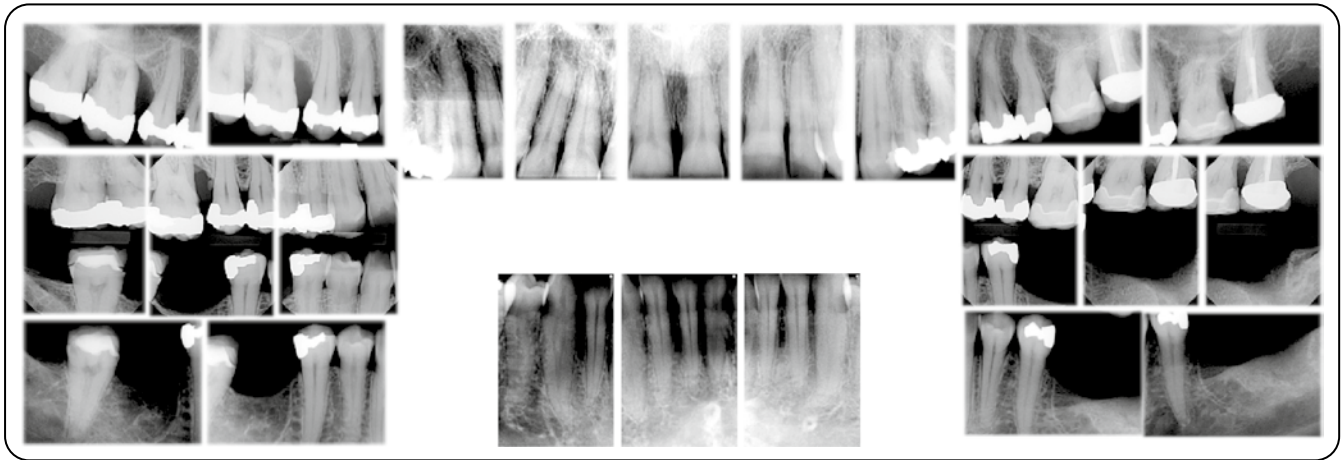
Complete series of intraoral radiographs.
